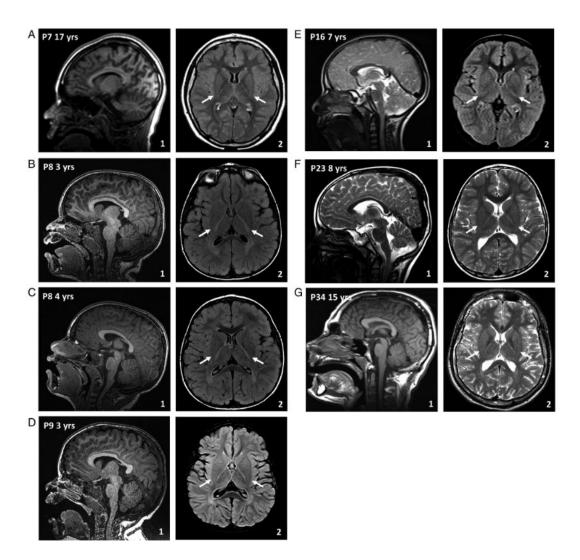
Individuals with biallelic pathogenic *ENTPD1* variants show white matter abnormalities, thinning of the corpus callosum, cerebellar atrophy, and signal abnormalities in the posterior limb of the internal capsule. Representative MRI of the brain of affected individuals from different families at different ages is shown. Arrows in the axial images highlight abnormal signal hyperintensity of the posterior limb of the internal capsule.
